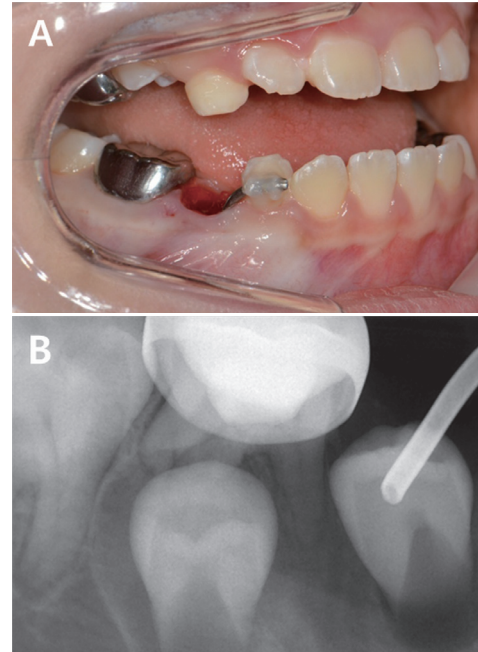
Intraoral photo (A) shows the decompression stent inserted through the extraction socket of the primary tooth involved. This new type of stent was stable with only resin bonding, so no other invasive procedure for fixation, such as a suture, was needed. The position of the metal tube relative to the lesion was checked radiographically (B).
